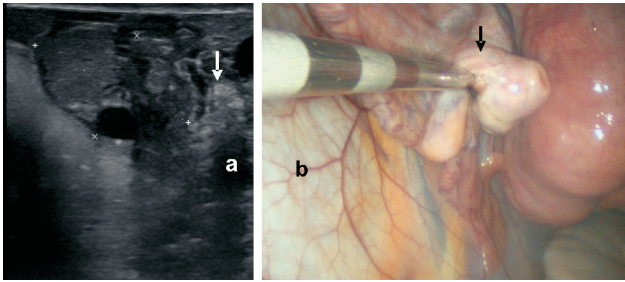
Ovarobursal adhesion (arrow). (a) Ultrasound image (b) Laparoscopic image.
